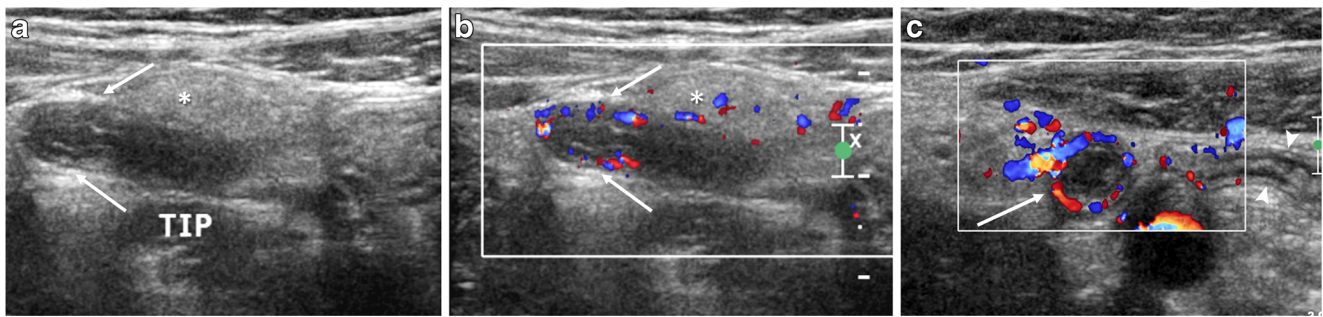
Distal tip appendicitis in a 13-year-old girl. a–c Longitudinal linear gray-scale (a), color Doppler (b) and transverse (c) US images show enlarged distal appendix (*arrows*) with hyperemia at the tip. Note
